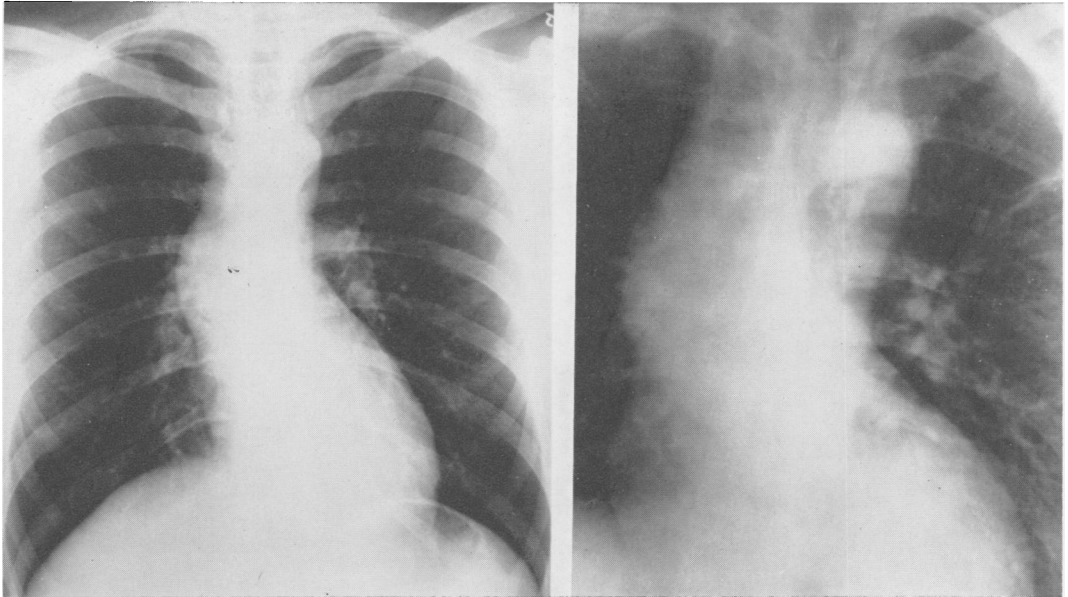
Case 2. 23-year-old man, asymptomatic. Studied because of murmur and dilated aorta. (a) (left) Roentgenogram showing large ascending aorta but normal heart. (b) (right) Angiocardiogram with dilated ascending aorta but normal valve and aortic arch.
